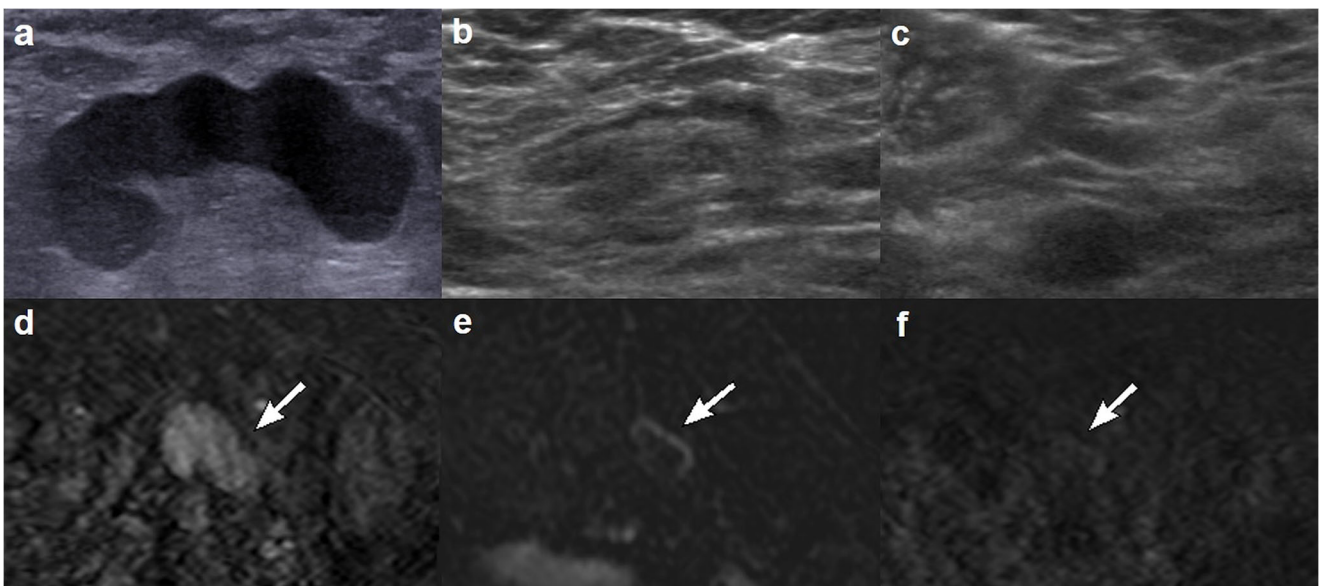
Axillary ultrasound and MR images of a 61-year-old woman given diagnosis of ER-negative/PR-positive/HER2-negative breast carcinoma with a fine-needle aspiration-proven metastatic lymph node in the left breast and axilla. Ultrasound image before neoadjuvant chemotherapy (a) shows a metastatic lymph node with cortical thickening of 10 mm with displaced hilum, which were assessed as positive findings. The lymph node shows cortical thickening of 3.1 mm during neoadjuvant chemotherapy (b) and disappears at US after neoadjuvant chemotherapy
